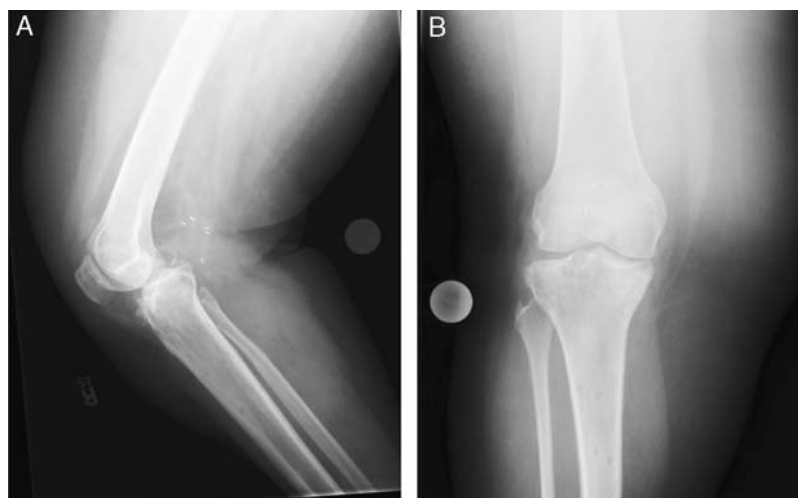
A, Anteroposterior and lateral (B) radiographic evidence of chronic, fixed posterior dislocation.
